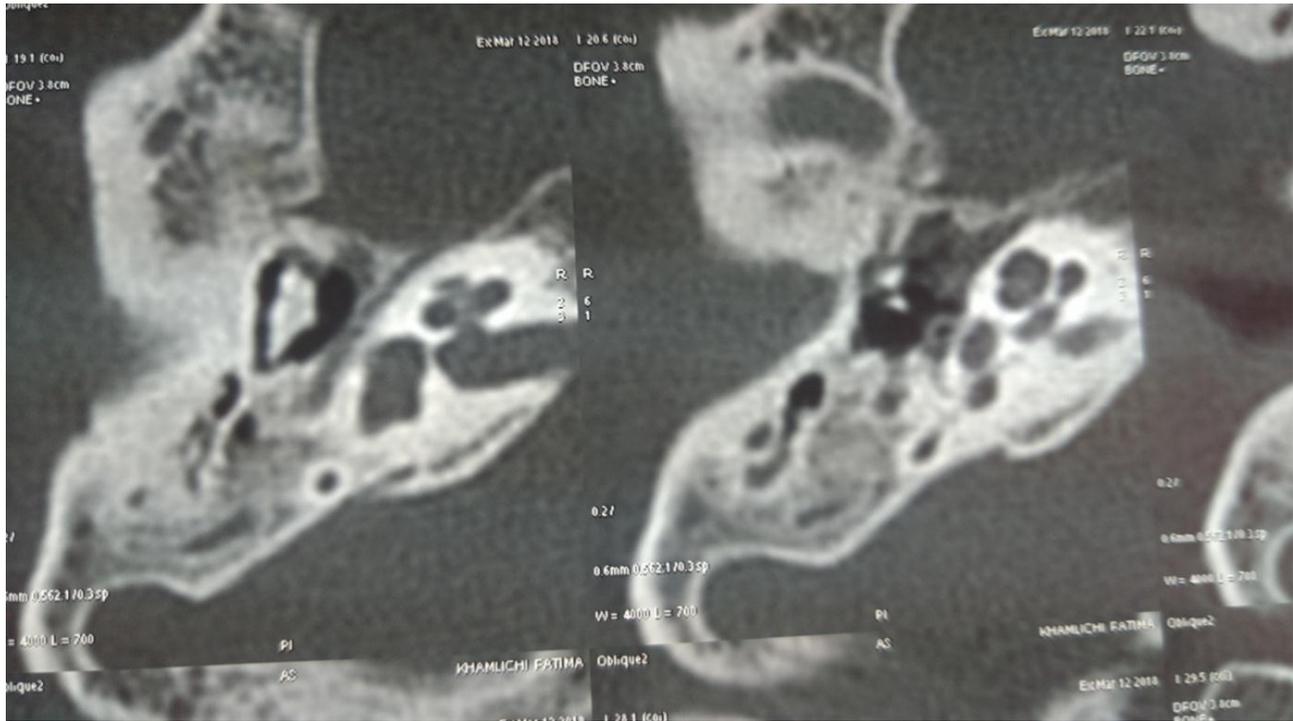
CT examination of a right bone in a bone window showing a bone bridge connecting the head of the hammer to the anterior wall of the attic, associated with a platinum thickening.
